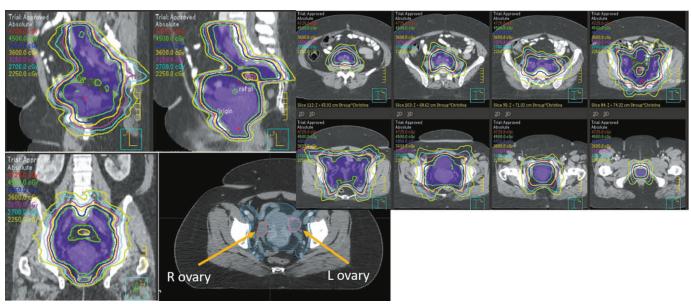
A typical pelvic radiation therapy plan using intensity-modulated radiation therapy, with ovaries identified on CT.
